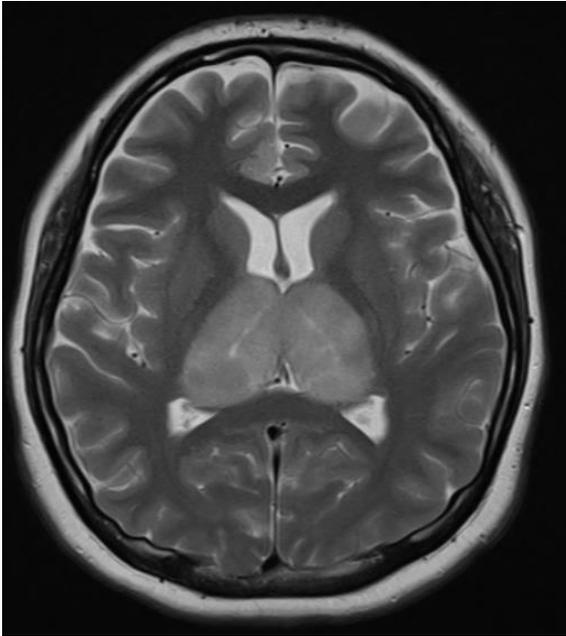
T2-weighted MRI sequence shows hyperintensity of both thalami.
